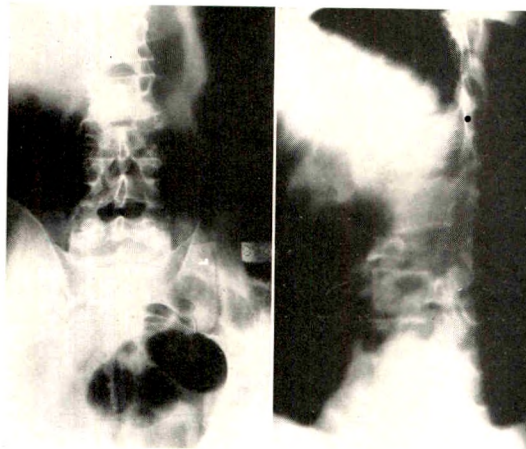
February 11, 1928. Preoperative roentgenogram showing additional destruction.
